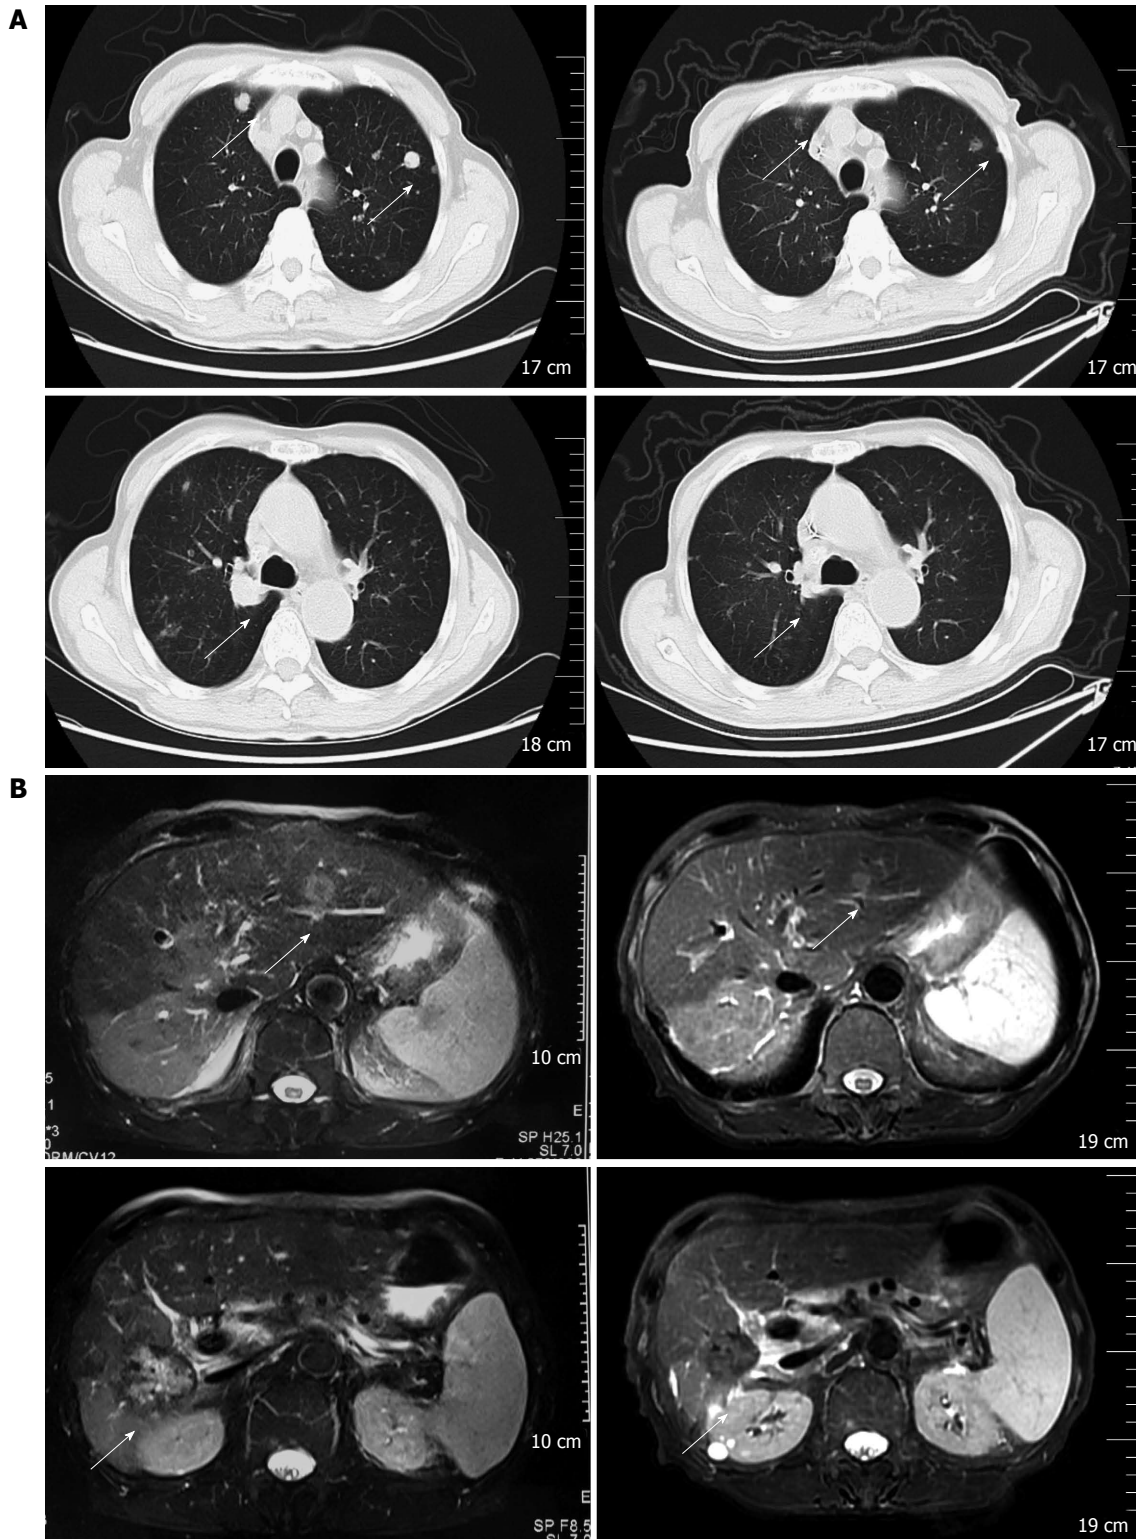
Computerized tomography scan (A) and magnetic resonance imaging (B). Before treatment (left figure) and after treatment (right figure) of the lung and the liver metastases, respectively; the response was confirmed after two additional cycles.
